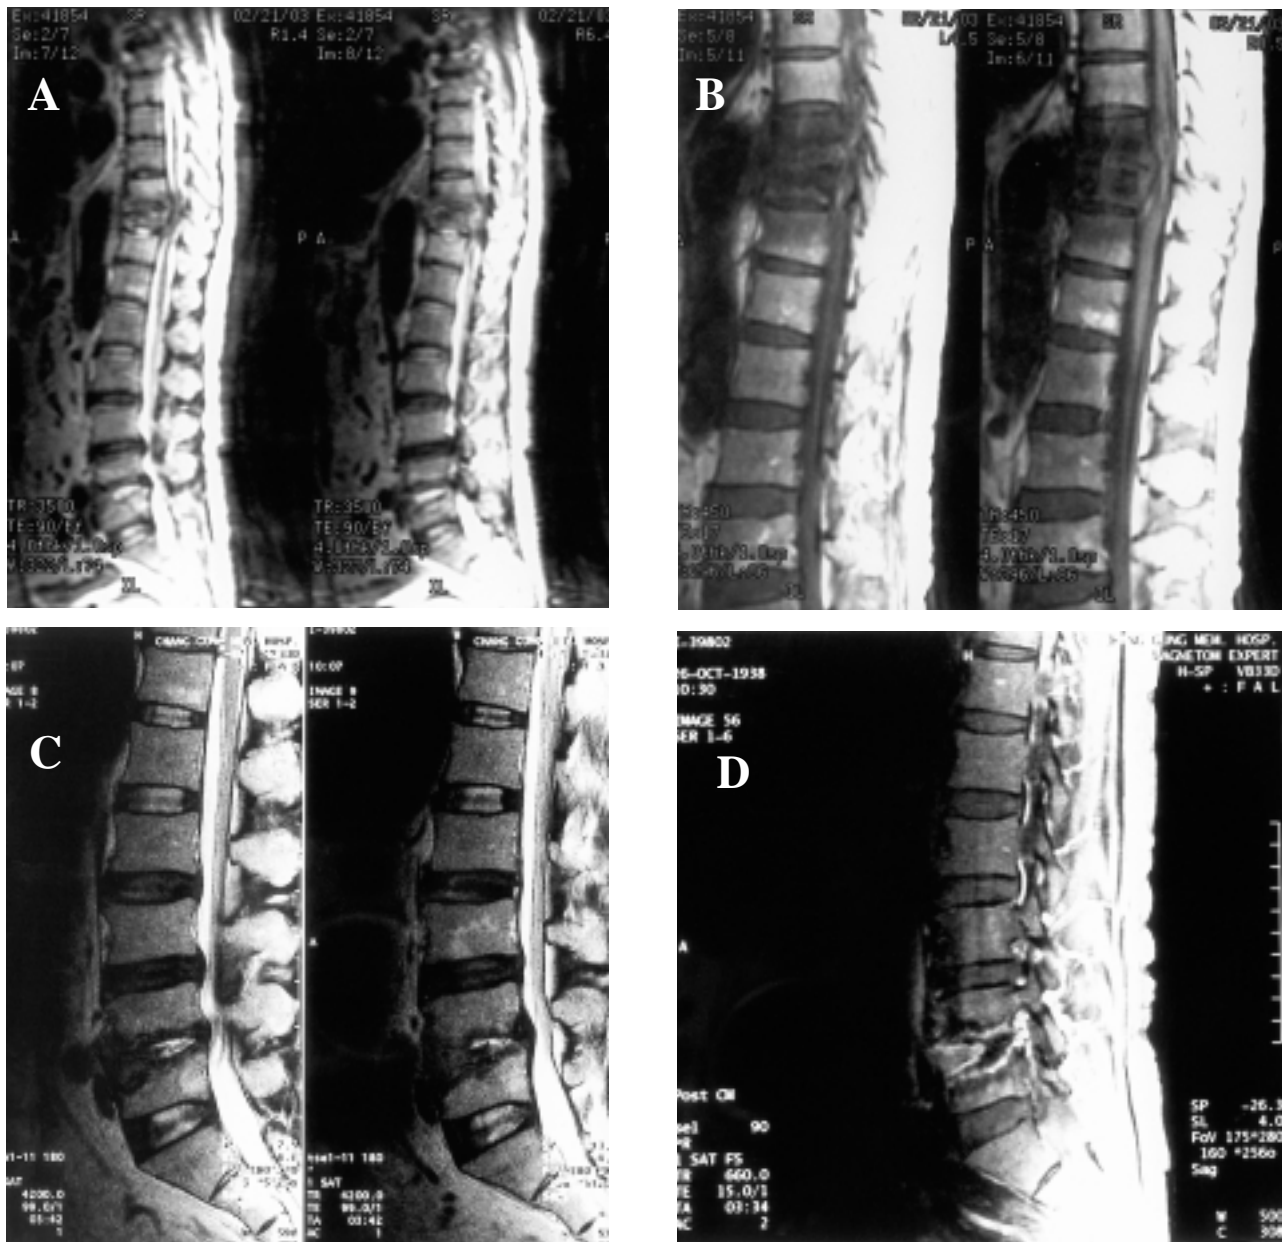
MRI (A) showing skip lesions at T9~T11 and L4~L5, respectively. Thecal sac compression was noted at T9~T11. T1-weighted image (B) of the thoracic spine showing disc space narrowing and endplate destruction between T9 and T10. T2-weighted image (C) of the lumbar spine showing abnormal disc signal change and endplate erosion at the L4~L5 discs. Gd-DTPA enhancement image (D) revealing abscess formation at L4~L5.
